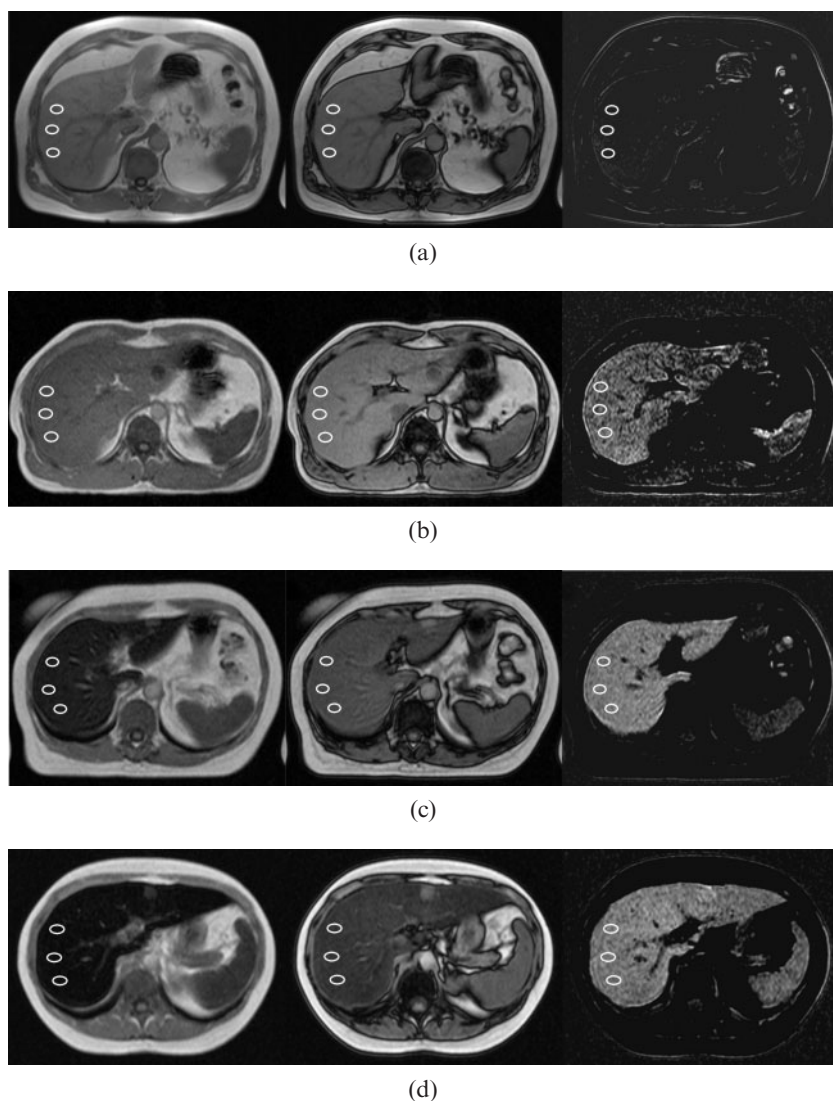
T*₁ weighted axial in-phase and out-of-phase images demonstrating the criteria of visual grading and measurements of relative signal intensity (rSI) difference method in four patients as examples of different grades of iron overload. Three regions of interests were obtained for the rSI analysis. Left, in-phase image; middle, out-of-phase image; right, subtracted image calculated as the signal intensity of the in-phase image minus the signal intensity of the out-of-phase image. (a) Normal iron concentration (Grade 0) with MRI-based hepatic iron concentration (M-HIC) of 33 $\mu\text{mol g}^{-1}$. (b) Minor iron overload (Grade 1) with M-HIC of 115 $\mu\text{mol g}^{-1}$. (c) Moderate iron overload (Grade 2) with M-HIC of 193 $\mu\text{mol g}^{-1}$. (d) Severe iron overload (Grade 3) with M-HIC of 271 $\mu\text{mol g}^{-1}$.
